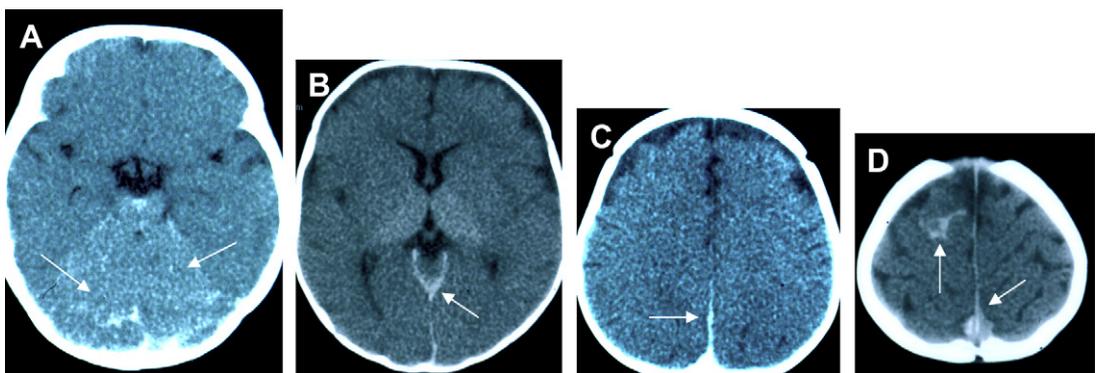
Six-month-old infant with triad and alleged NAI; acute choking event while feeding. CT (A–D) shows bilateral cerebral edema with acute SAH and SDH (arrows), including along the falx, and tentorium. Autopsy confirmed the hemorrhages, a subdural membrane, and hypoxic-ischemic brain injury. (Courtesy of The Wisconsin Innocence Project.)
